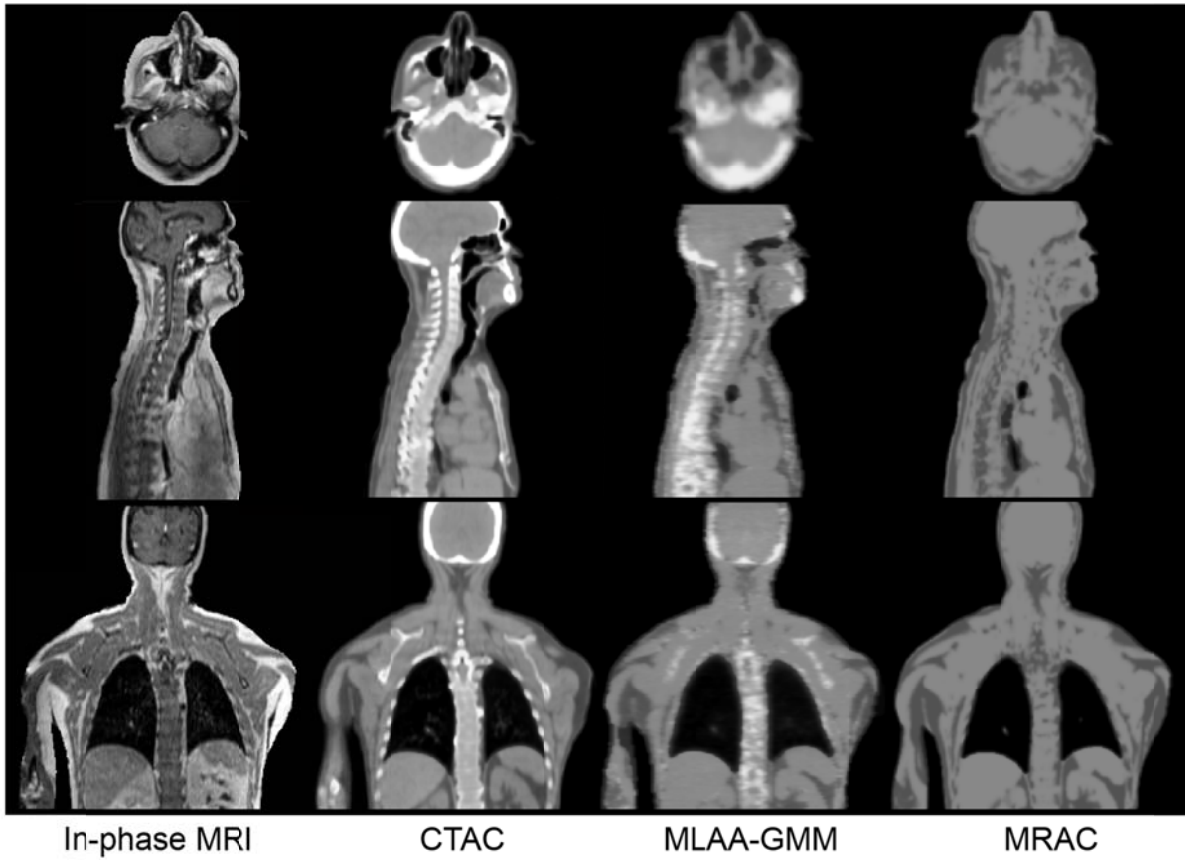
Comparison of 4-class MRAC and MLAA-GMM attenuation maps with their reference CTAC map from a representative ^{18}F -FDG PET/CT/MRI study. The display window is $0.08 \pm 0.055 \text{ cm}^{-1}$.
